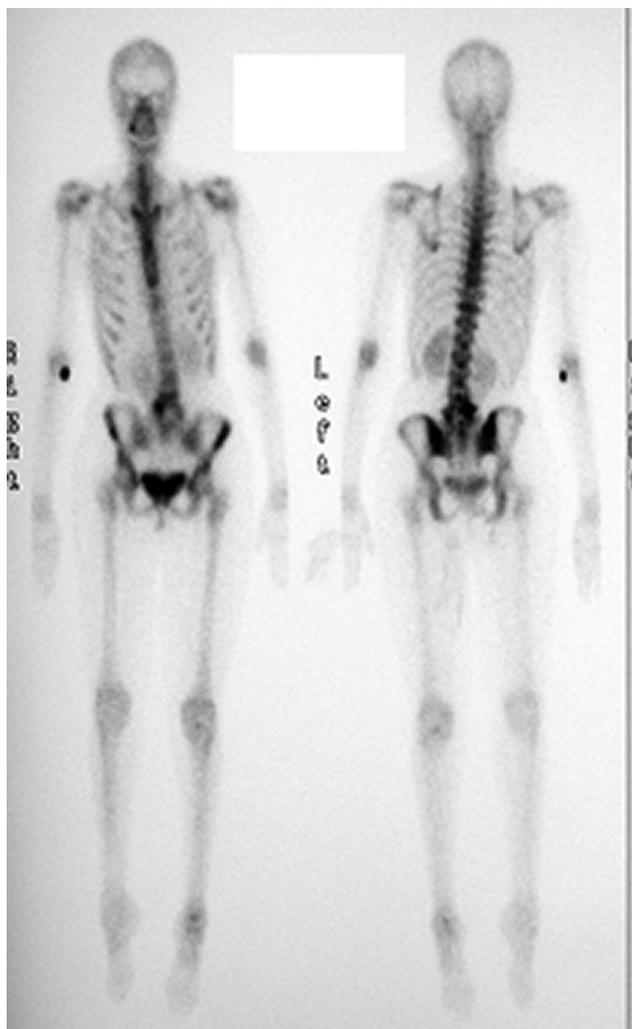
Whole body technetium bone scan—static image acquired at 4 hours. This demonstrates a focus of increased activity (black arrow) in L5 with associated scoliosis. The subtle increased activity in T6 (white arrow) was shown to represent a focus of marrow replacement in T6 on MRI (not shown). The focus of activity at the right elbow corresponds to tracer extravasation at the injection site.
